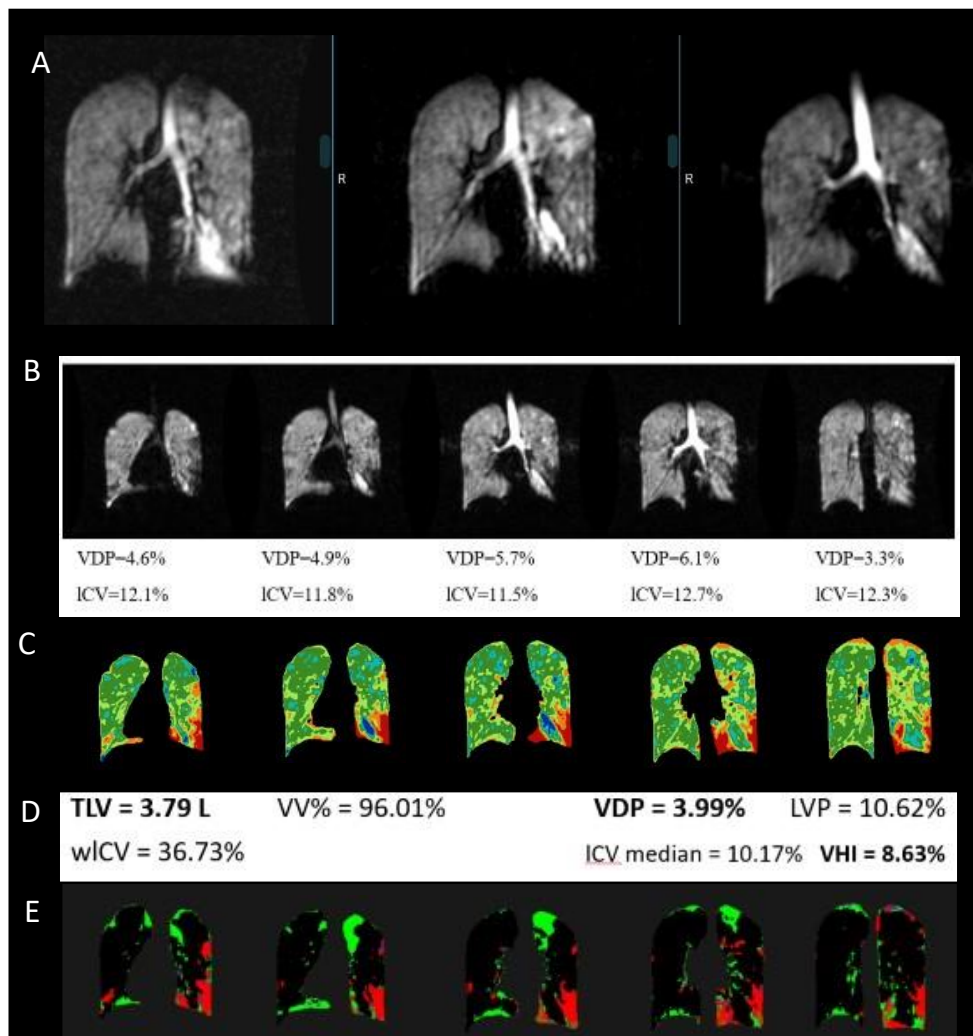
Example of ^{129}Xe MRI imaging data at the 4-hours post-ACT timepoint reviewed by clinicians. A depicts the side-by-side comparison of images on XNAT comparing pre-ACT (left), post-ACT (centre) and 4-hours post-ACT (right). B, C and D depict excerpts from the technical report showing the raw images (B), ventilation binning maps (C), whole lung metrics (D). E depicts an excerpt from the treatment response (pre to 4-hours post-ACT).
